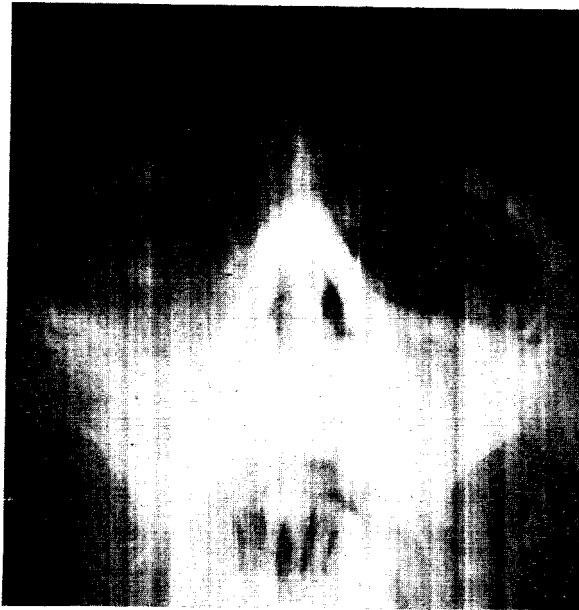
Case 9.—X-ray film showing erosion of floor of the right orbit by squamous cell carcinoma of the right antrum.
